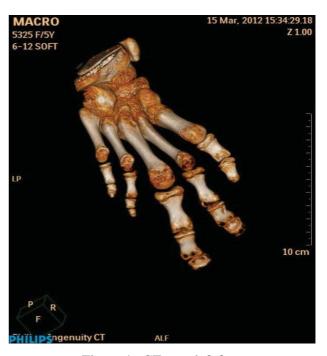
CT scan left foot
